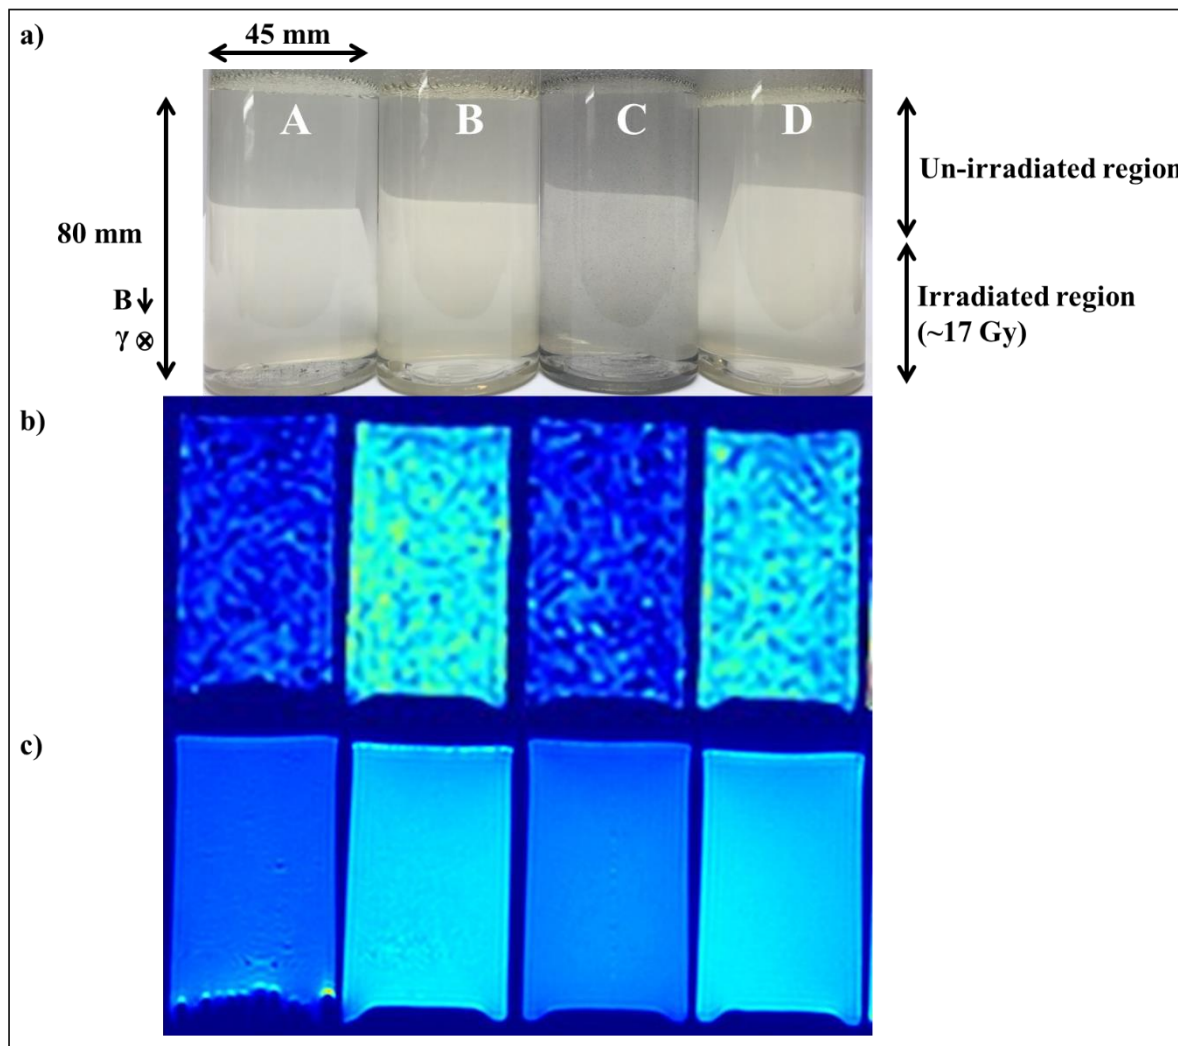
a) Pictures of physical dosimeters where A – FOST, B – FCST, C – FPST, and D – FASST. The top half of each gel was not irradiated, and the bottom half was irradiated to approximately 17 Gy. b) Snapshots of bFFE acquisitions with $TR/TE = 5/2.4$ ms. c) Post-irradiation acquisitions with TSE $TR/TE = 500/20$ ms. MR images shown with color instead of grayscale to emphasize contrast.
